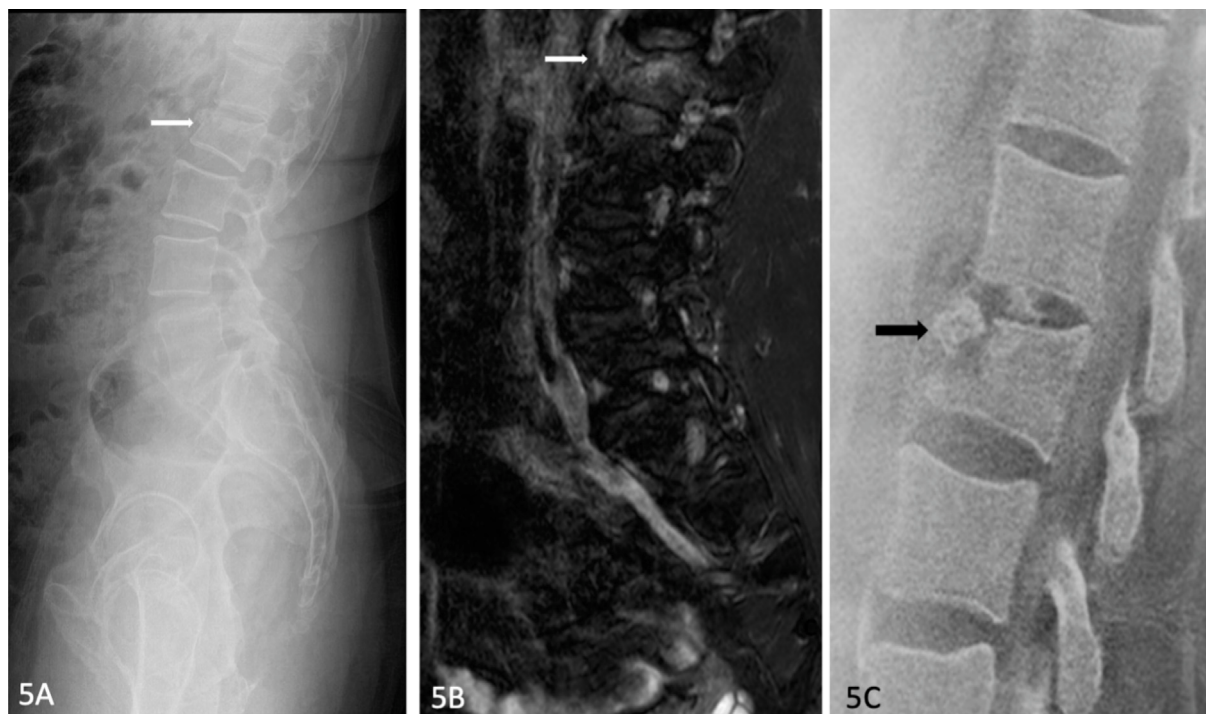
45-year-old male with traumatic fracture of the L2 vertebral body. (A) Lateral lumbar radiograph showing the L2 vertebral body fracture. (B) Sagittal T2-weighted MRI showing cortical break and bone oedema. (C) Sagittal BTFE showing a wedge compression fracture of the L2 vertebral body, with the fracture line through the antero-superior corner better visualized (arrow).
